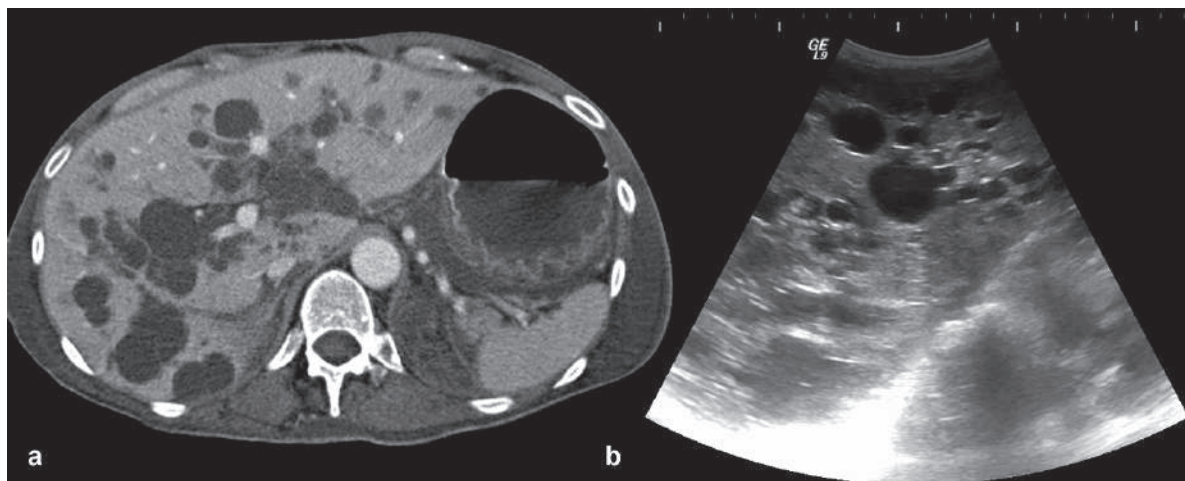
Axial CT postcontrast (a) with liver ultrasound (b) images show multiple liver cysts in a patient with ADPKD
